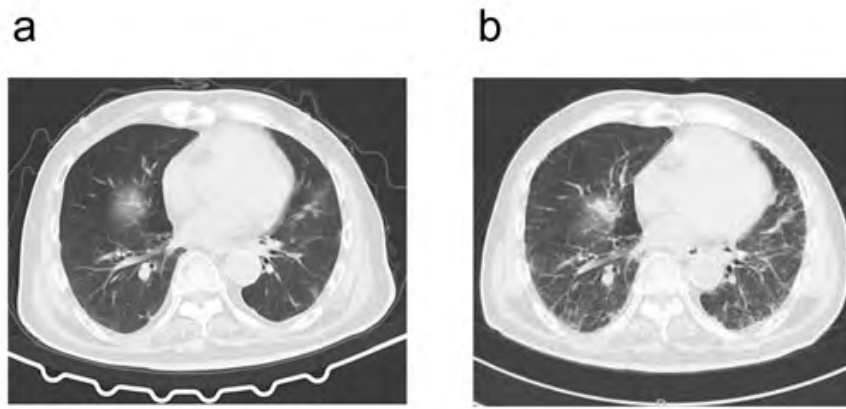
Side effects that occurred during the treatment of immunotherapy. (a) Chest CT imaging of pneumonia in the bilateral lungs during immunotherapy combined with double-agents chemotherapy. (b) Chest CT showed interstitial lesions of both lungs during immunotherapy combined with single-agent chemotherapy.
